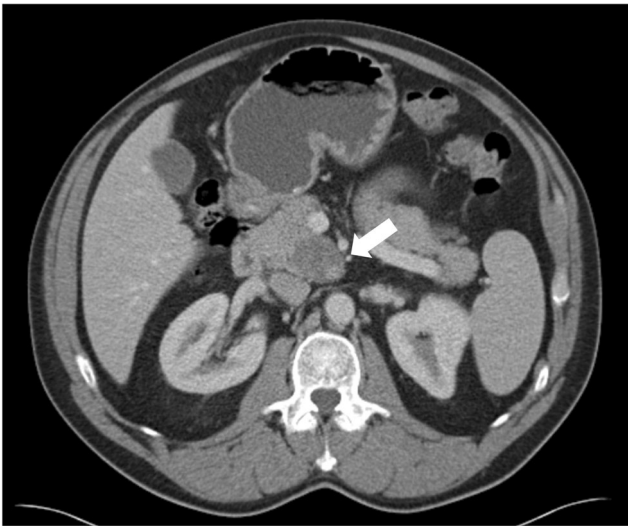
CT scan of a 62-year-old male demonstrating a 3.8-cm mass arising off the medial aspect of the uncinate process. No intrahepatic or pancreatic duct dilatation was observed. The mass was well defined but had cystic features. Furthermore, there was peripheral enhancement of the lesion. Presumed diagnosis was a pancreatic cystic lesion
